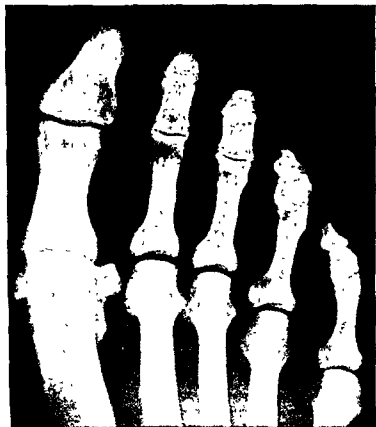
Roentgenogram of the right foot of a 35 year old male who has suffered intermittent attacks of acute gouty arthritis since the age of 9. Originally the symptoms were attributed to acute rheumatic fever. The subsequent course suggested that gouty arthritis was responsible. The family history is positive for gout. The concentration of serum uric acid was 8.3 mg/100 ml. Areas of decalcification are present in the head of the first metatarsal and the head of the proximal phalanx.
